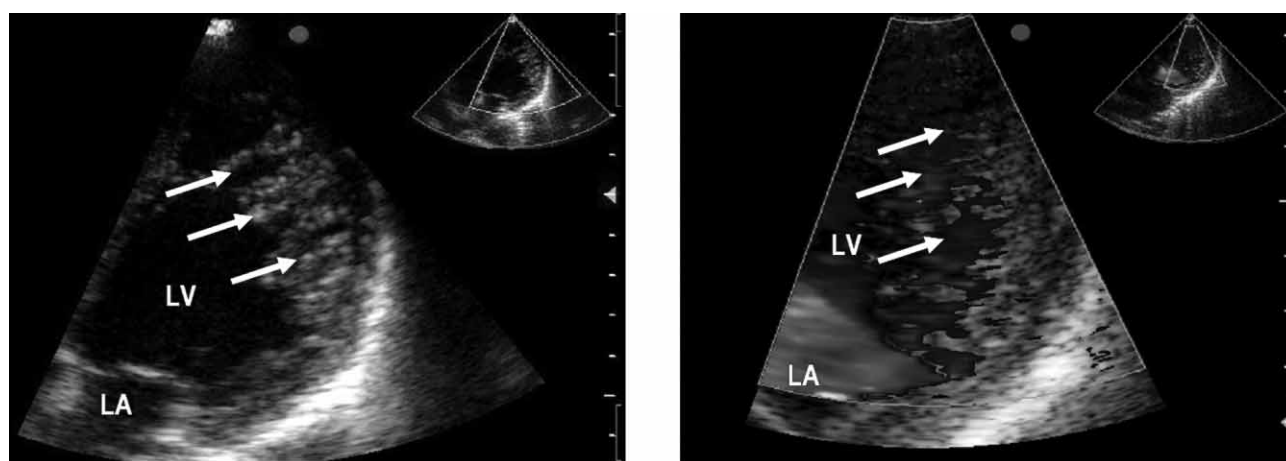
a) Apical 4-chamber view, shows dense left ventricular trabeculations with deep intertrabecular recesses. b) Color-flow imaging shows communication between intertrabecular spaces and the left ventricular cavity. LV – left ventricle, LA – left atria, arrows indicate non-compacted left ventricle.
